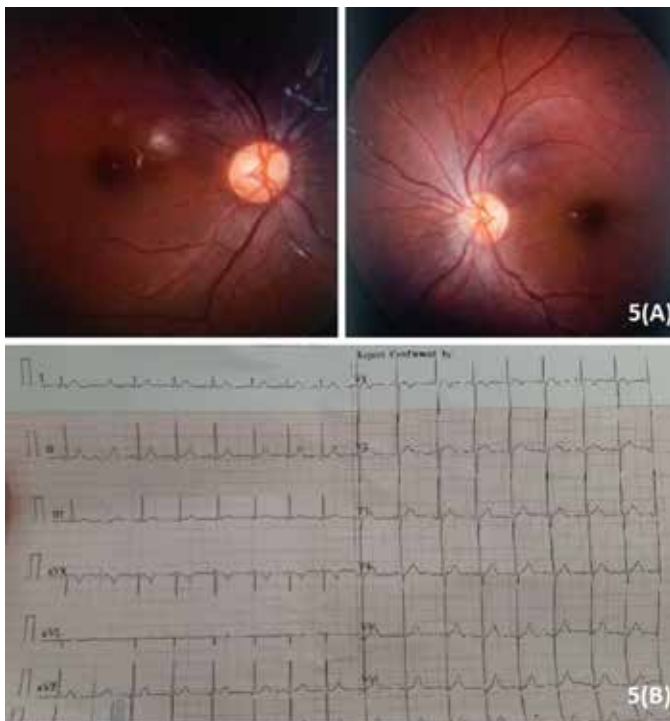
(5A) Colored fundus photograph showing normal optic disc and central fundus (5B) Normal Echocardiography of patient
